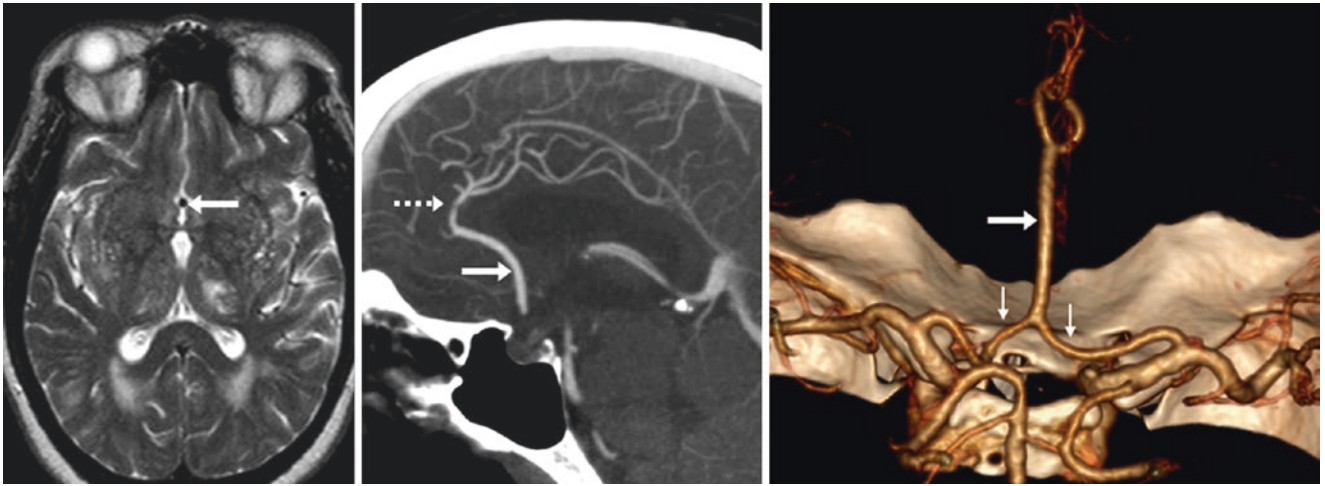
In this 61-year-old vasculopath, a T2WI MRI (*left*; note diffuse T2-bright lesions) shows an azygous ACA (*large arrows*), as only one midline A1-A2 segment is seen. A midline MPR (*middle*)
